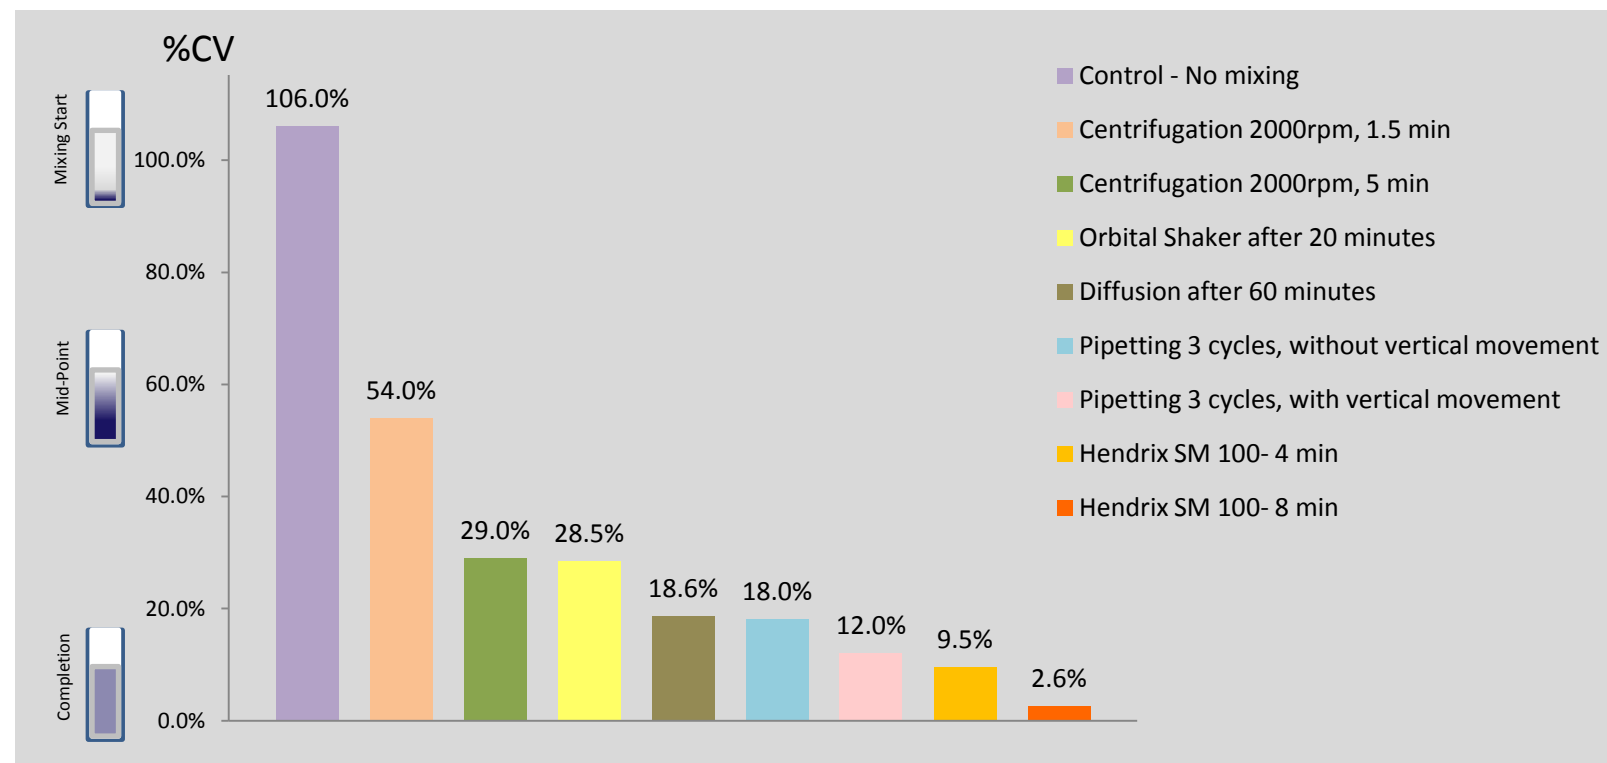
When we examined the mixing effectiveness of the five methods, spinning plates in the centrifuge for 90 seconds was ineffective (54% CV) and even after 5 minutes centrifugation could not fully mix the wells (29% CV). Shaking plates for 20 minutes was also ineffective (28.5% CV). Mixing by diffusion took 60 minutes to reach 18.6% CV; pipetting repeatedly did reduce the %CV but contacting samples could introduce other issues. The most effective way to mix a small volume of a DMSO sample into water in 384-well plates was using non-contact Lateral Ultrasonic Thrust technology. The HENDRIX SM100 achieved 9.5% CV in 4 minutes and 2.6% CV in 8 minutes.
